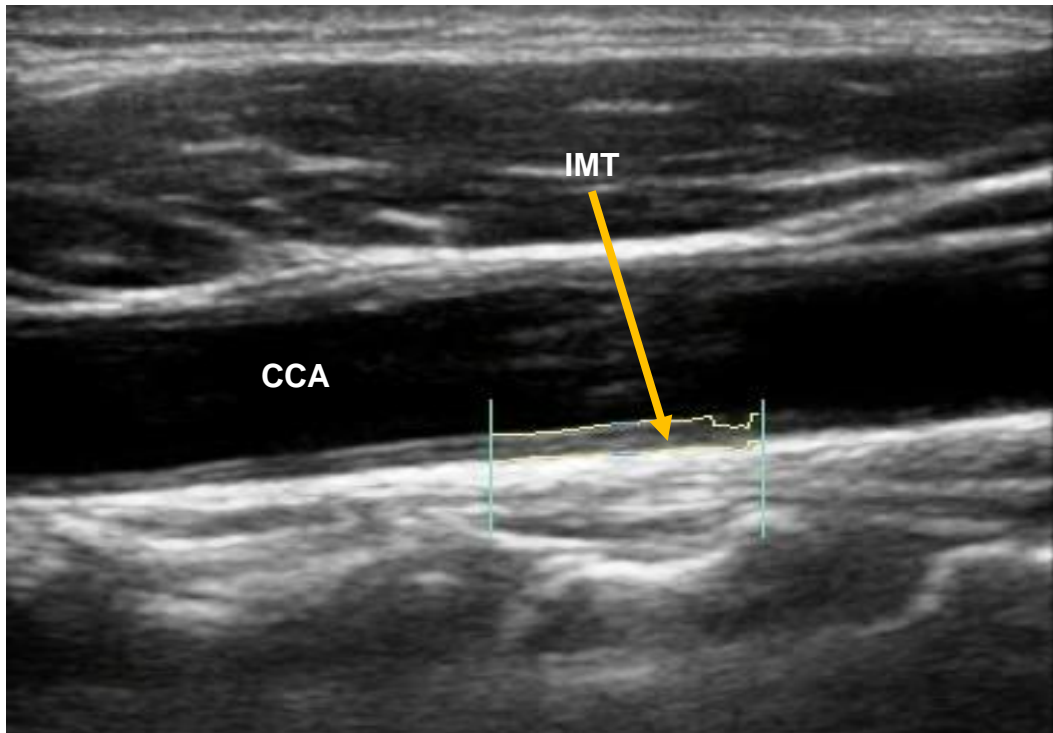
An ultrasound image of the common carotid segment and IMT measurements represented by the two yellow lines parallel to the lumen using semi-automated border-detection and quality control software. (CCA: Common carotid artery, IMT: Intima-media thickness).
